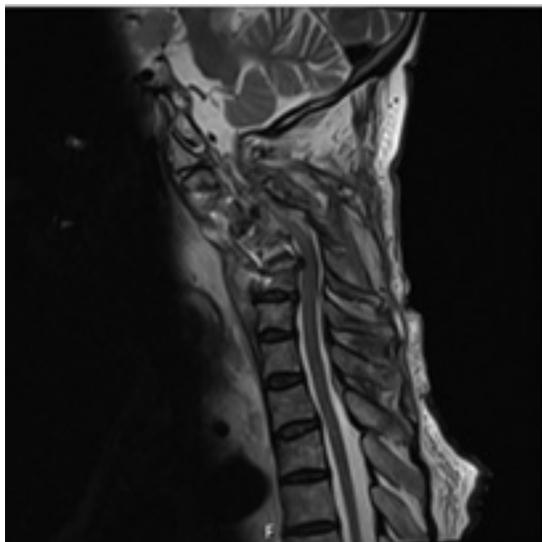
Cervical spine MRI showing prevertebral collection and collapse of C5 vertebral body.
